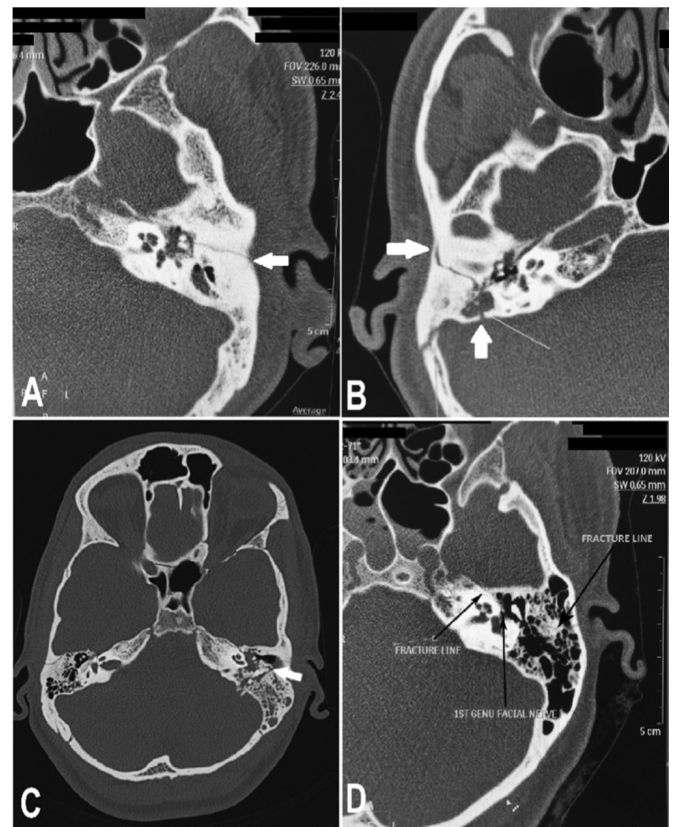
High resolution CT scan of temporal bone. (A) Axial image shows longitudinal fracture line involving the left temporal bone (white arrow). (B) Axial image shows an oblique fracture line involving the right temporal bone (white arrow). (C) Axial image shows displaced bony fragments along the fracture line (white arrow). (D) Axial image shows a fracture line in the left temporal bone involving the first genu of the facial nerve (black arrow)
